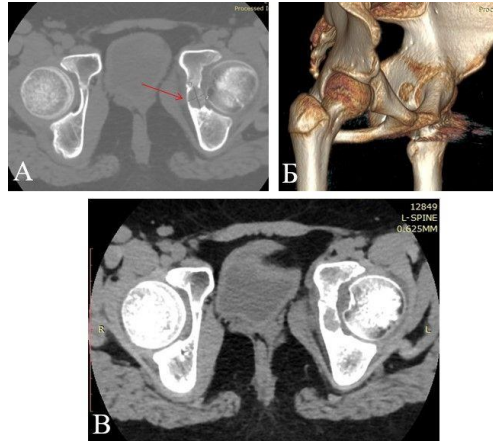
A, B, C – CT showing the presence of an osteolytic lesion in the region of the left acetabulum.
